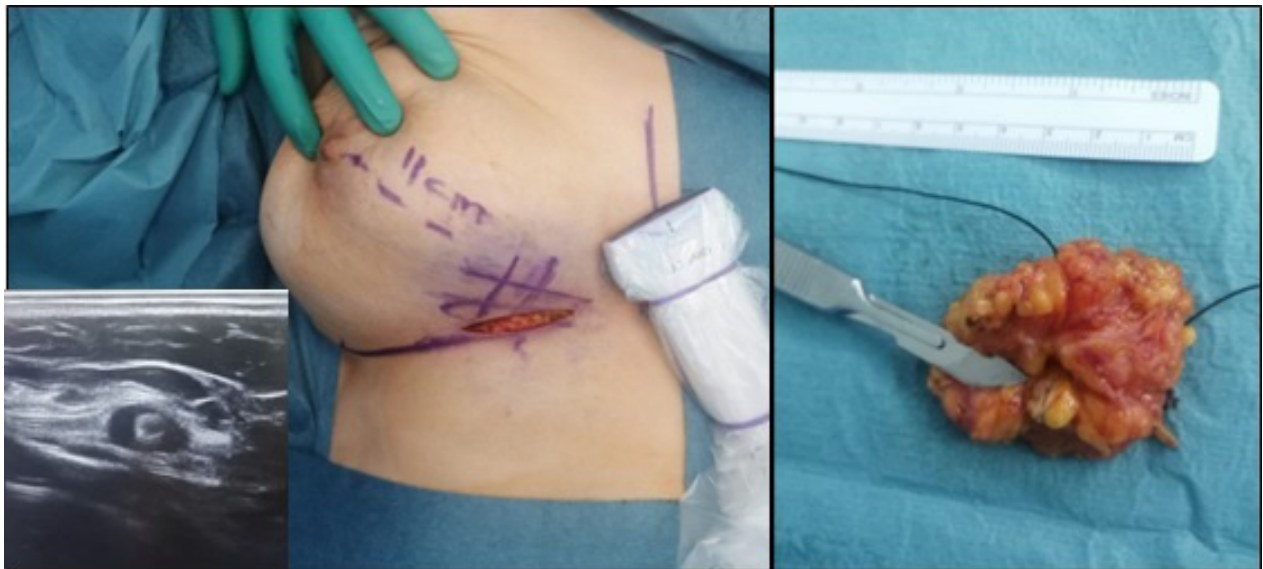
Ultrasound- guided wide local excision of right breast lesion (Left), lesion shows at the tip of the blade with surrounding surgical margins (right).
